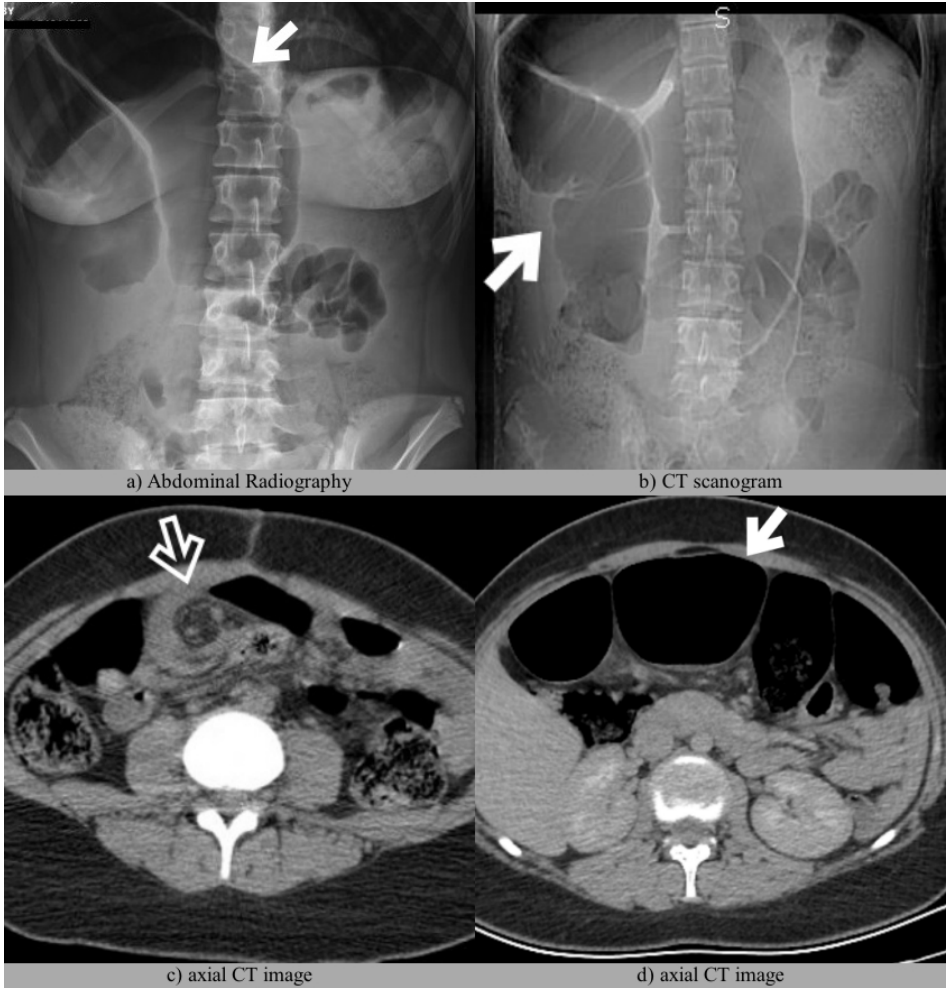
a-d (a) Abdominal radiography, (b) CT scanogram, and (c), (d) axial CT images of a patient with complaints of abdominal pain.
